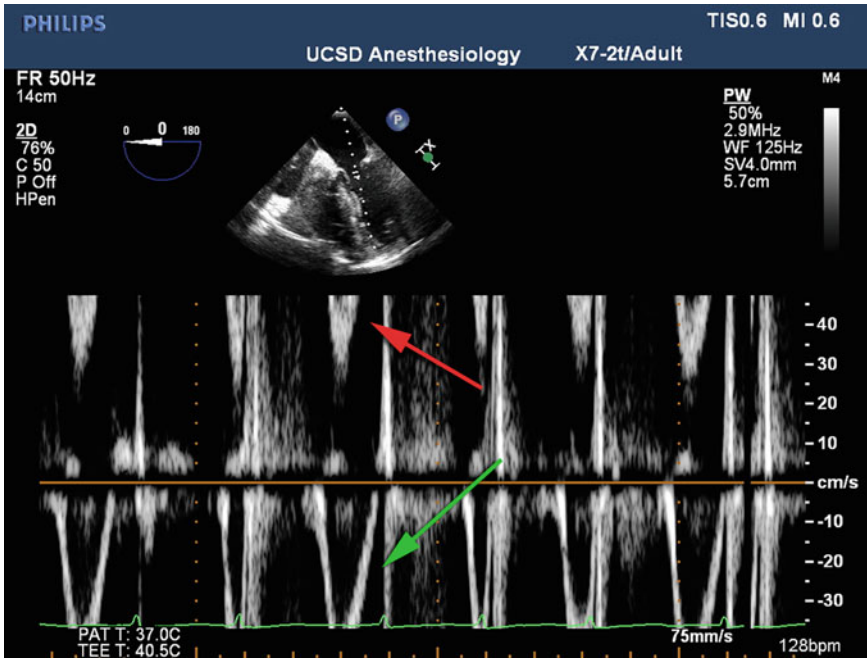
Pulse Wave Doppler of transmitral flow. Flow away from the transducer is displayed as below the zero line. Flow becomes so rapid (*green arrow*) that it is displayed as flow in the opposite direction (*red arrow*, “Wrap Around”)
